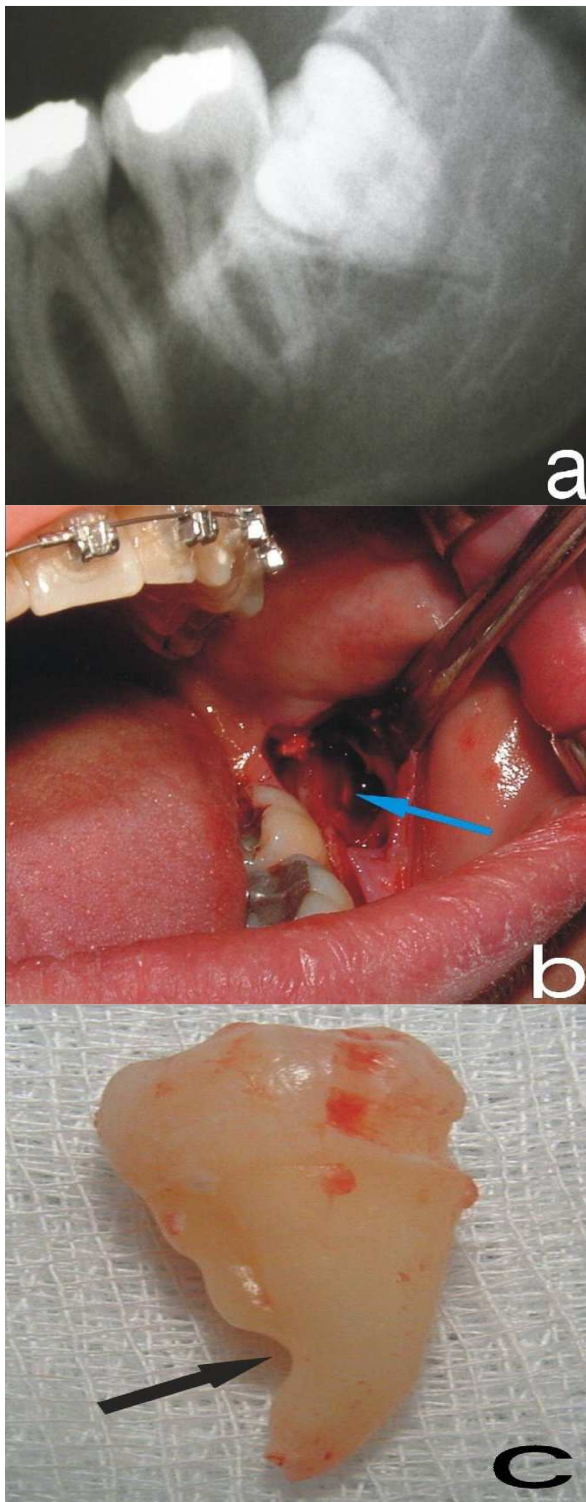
(a). Darkening of the root and slight narrowing and deflection of the canal are evident on the panoramic radiograph of the mandibular third molar (reproduced from Szalma et al [2]. with permission from Elsevier); (b). The inferior alveolar nerve (blue arrow) is clearly visible intraoperatively (reproduced from Szalma et al. [2] with permission from Elsevier); (c). After the extraction, a groove is seen on the lingual surface of the root (reproduced from Szalma et al [2] with permission from Elsevier)
